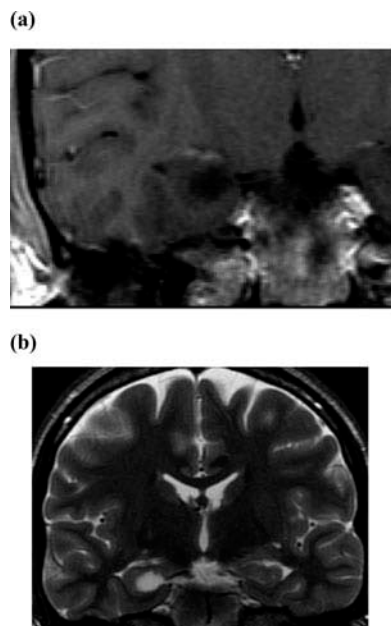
MRIs showing a nonenhancing lesion in the body of the right hippocampus in Subject 1: (a) T1-weighted MRI, the lesion had low signal; (b) T2-weighted MRI the lesion had high signal intensity.
